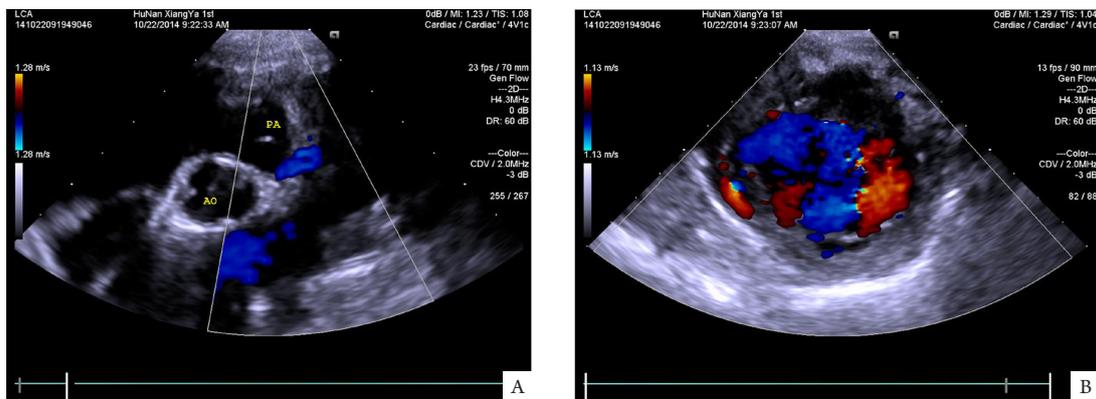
Color Doppler echocardiography
